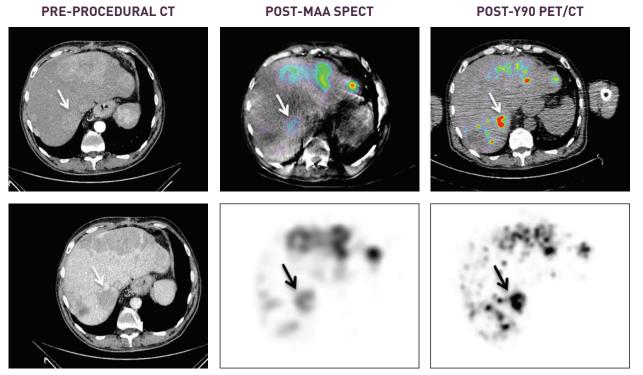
Example of a patient with a hypervascular NEM tumor in segment 7. (left column) Arterial and portal phase CT. (centre column) Post-MAA SPECT imaging. <sup>99m</sup>Tc-MAA planning infusion delivered via EH catheter resulted in a T/N of 2.9 and a tumor dose of 69 Gy. (right column) Post-Y90 PET/CT imaging. Resin Y90 RE delivered via PEDD resulted in a T/N of 8.4 and a tumor dose of 172 Gy. This corresponds to a 189% increase in T/N and a 149% increase in tumor dose for this patient compared to the MAA delivery.
